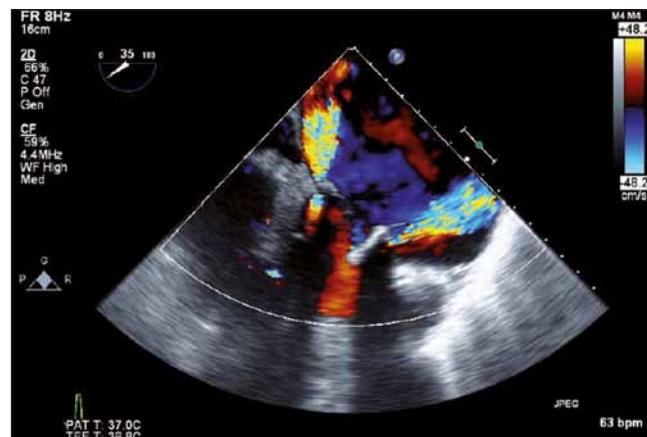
Preoperative transesophageal echocardiography showing a significant mitral paravalvular leak.
